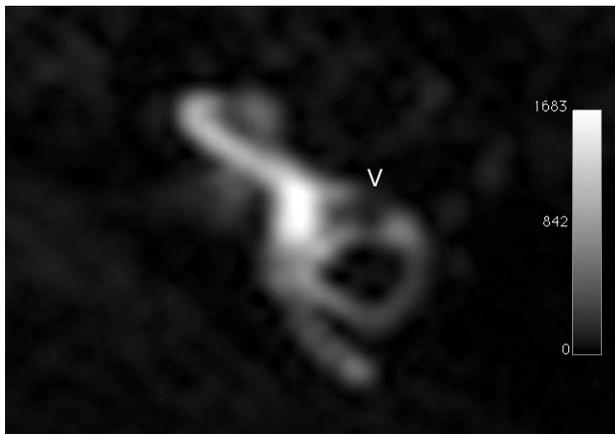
Positive perilymph image (PPI) – 3D FLAIR sequence. A 2500 ms IT on 3D-FLAIR sequence causes a positive longitudinal magnetization of the perilymphatic fluid filled with contrast agent and a negative longitudinal magnetization of the endolymphatic fluid and surrounding bone. Consequently, 3D-FLAIR sequence produces positive perilymph images. Arrowhead indicates a filling defect of CE in the lateral semicircular canal.
